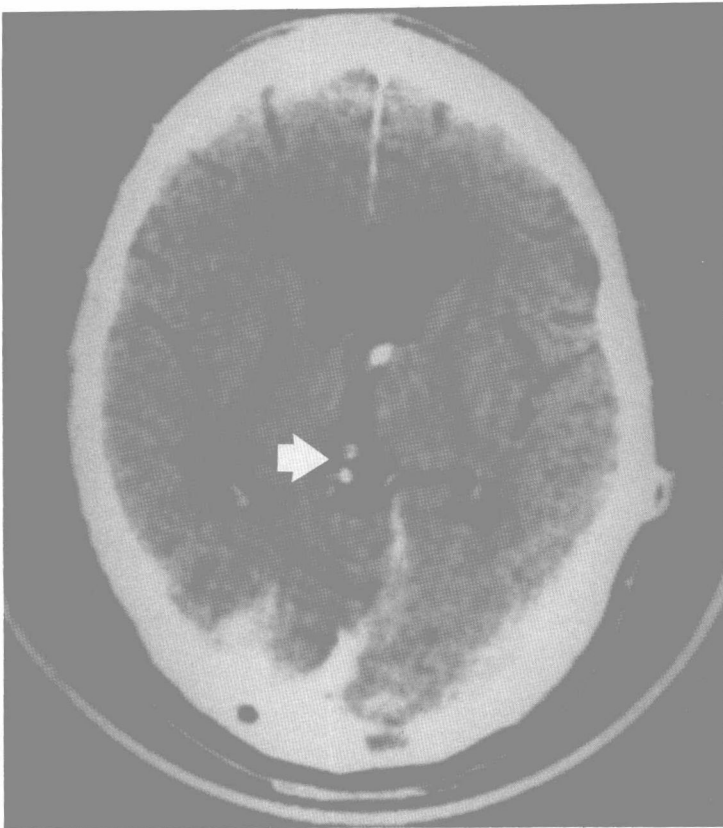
Postoperative CT scan 9 months following surgery and radiotherapy, no longer demonstrating an enhancing pineal region tumor. There is a small amount of calcification that remains in the pineal region (arrow).
